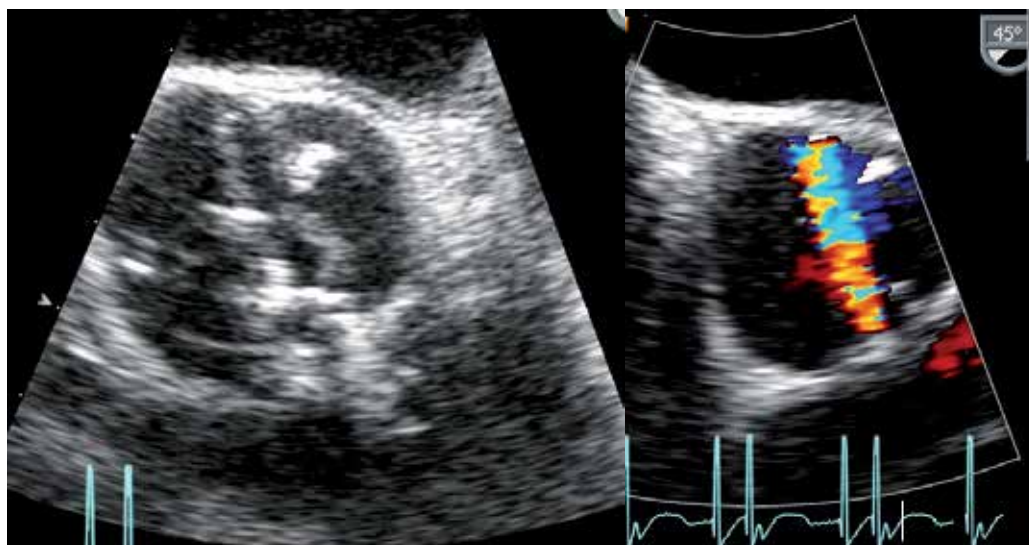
Using transesophageal echocardiography in a patient with calcific aortic stenosis, a bicuspid valve morphology is detected and planimetry of the aortic valve area can be reliably performed.
